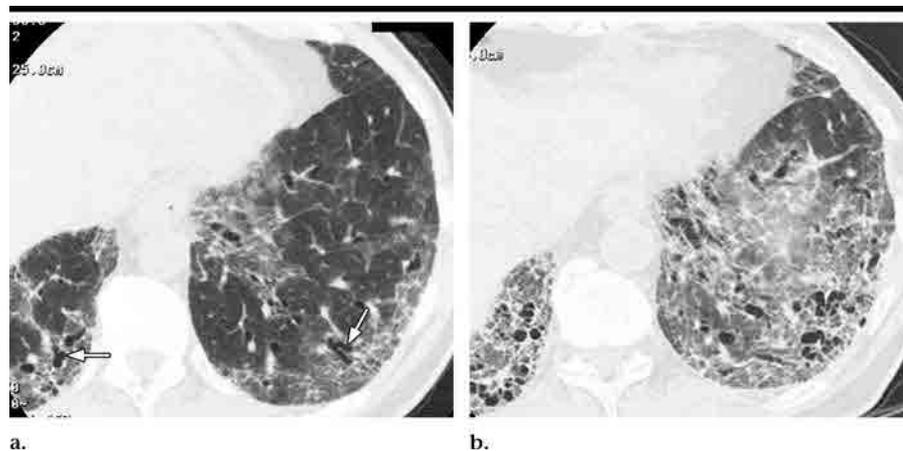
Transverse CT images in a 65-year-old man with progressive shortness of breath due to UIP. (a) Left lower lobe shows peripheral ground-glass opacity and reticular patterns with traction bronchiectasis (arrows). (b) Two years later, ground-glass opacification has progressed to reticular pattern and honeycombing, with progression of traction bronchiectasis.
